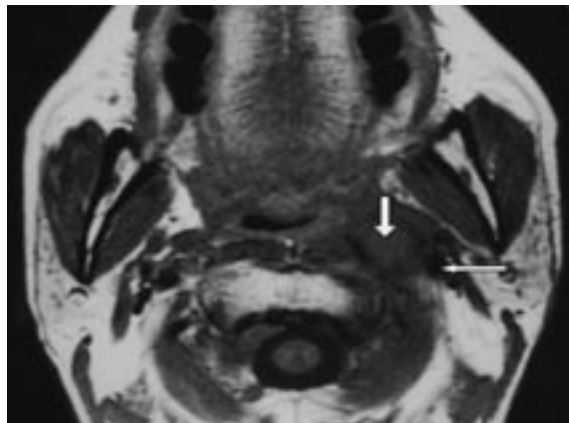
Axial T1-weighted MR image shows the SCSG (thick arrow) with anterior displacement of the internal carotid artery (thin arrow).
